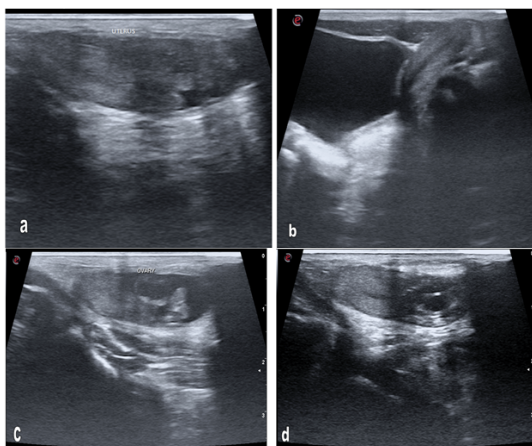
(a): High frequency ultrasound images of left inguino-labial swelling depicting completely herniated uterus and cervix. Few bowel loops are also seen in hernia sac. Figure 2(b) Ultrasound image showing herniation of the uterus on straining with empty pelvic cavity and uterus lying at the level of deep inguinal ring. Figure 2 (c) and (d)
